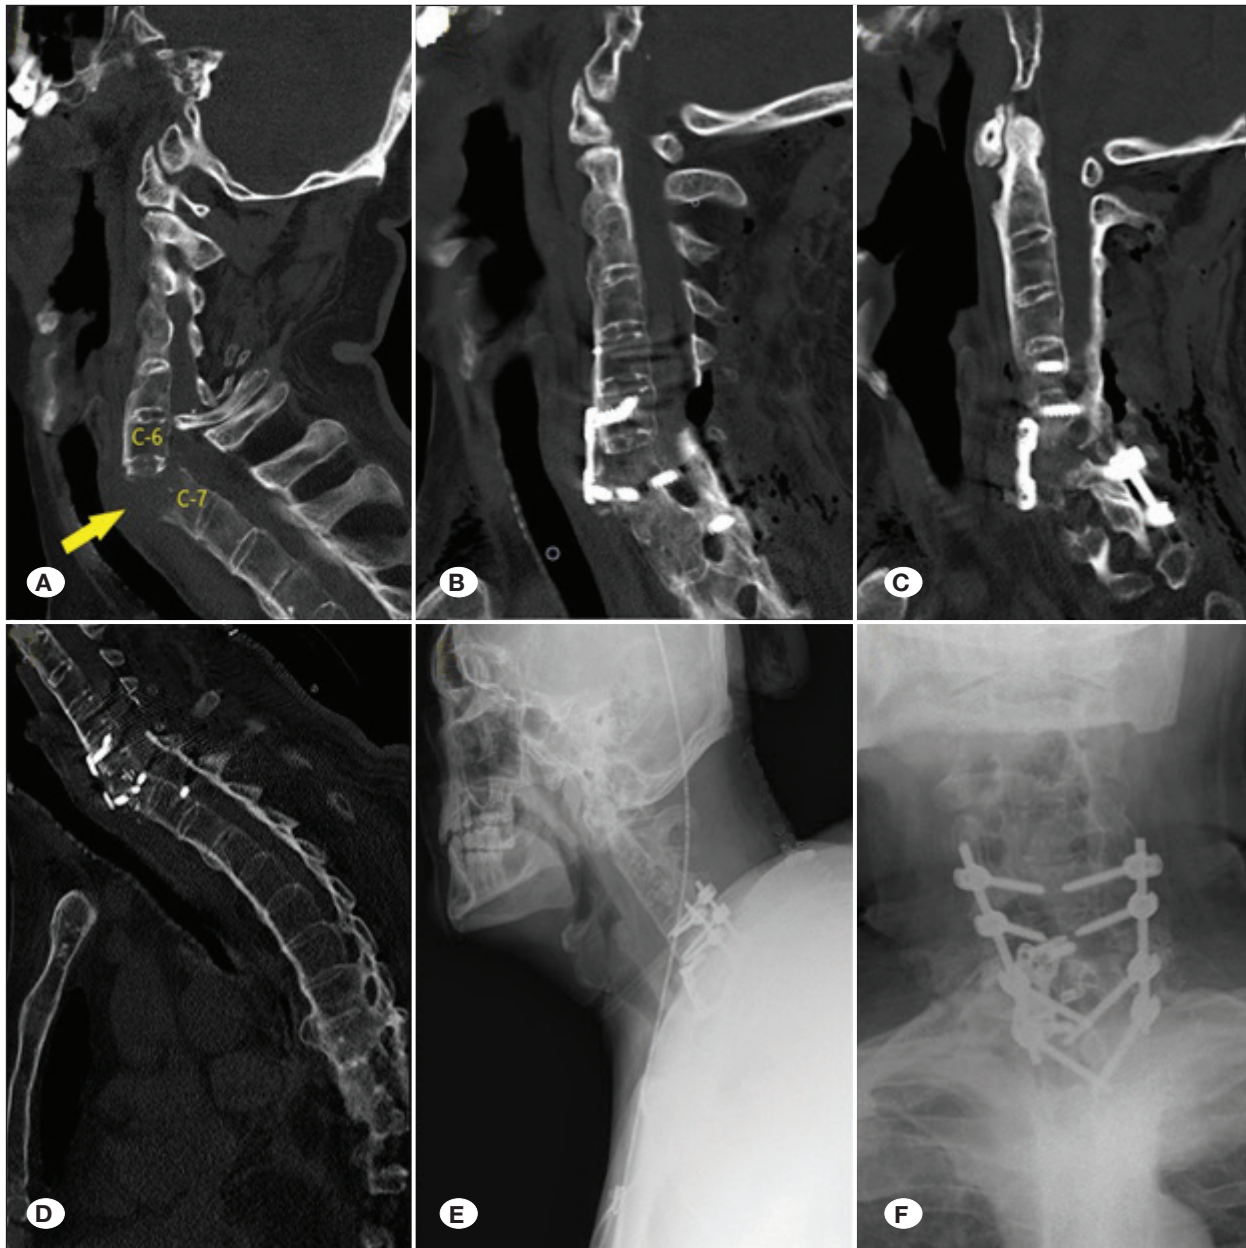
C6–7 Fracture and dislocation + clearance in anterior + anterior posterior fusion A) Preoperative CT, B–D) Postoperative CT, E–F) Postoperative radiography. The yellow arrow indicates the angling and cavity in the fracture area. CT: Computed tomography.
